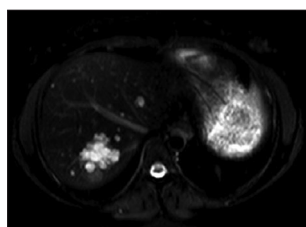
Magnetic resonance imaging - abdomen (September 2012)
